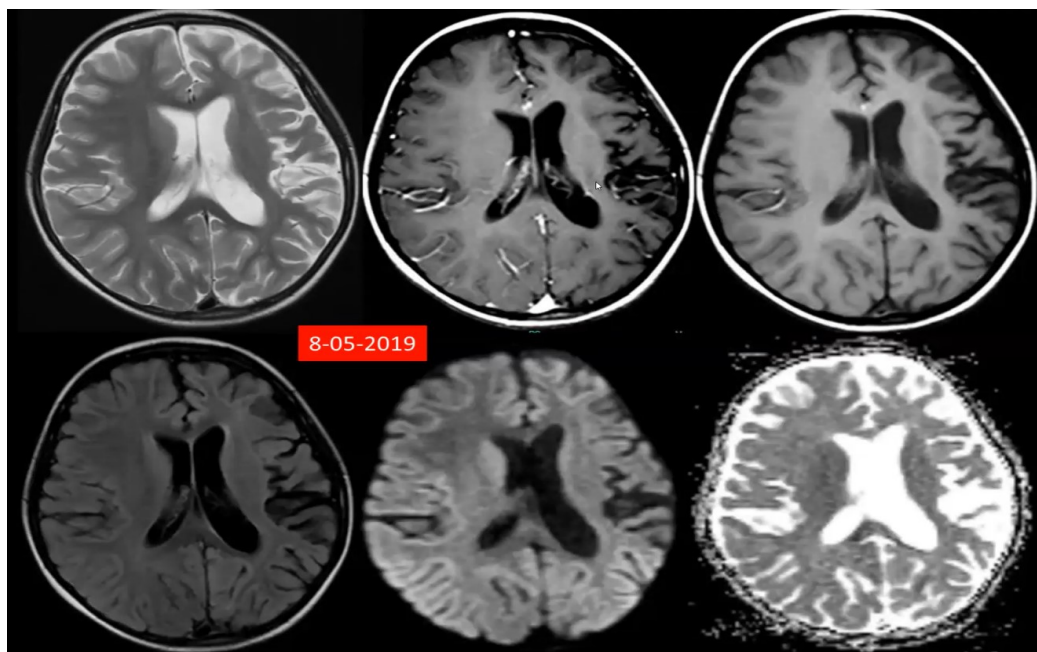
Cranial MRI in 2019 showing progressive left cerebral hemiatrophy, without evidence of contrast enhancement.
